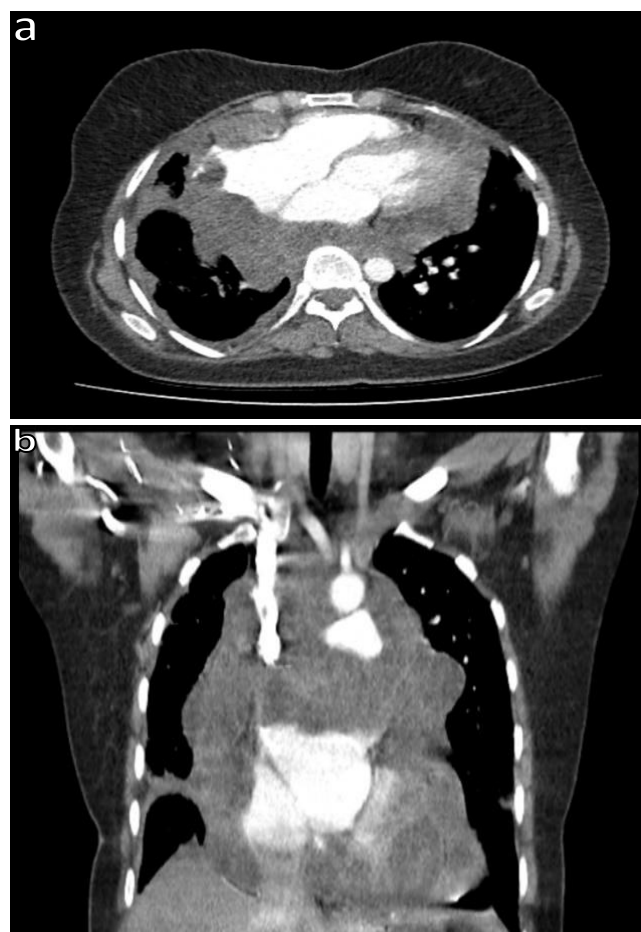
Cystic lesion in the mediastinum on a contrast-enhanced thorax CT of the case, axial section (a), Cystic lesion in the mediastinum on a contrast-enhanced thorax CT of the case, coronal section (b)
